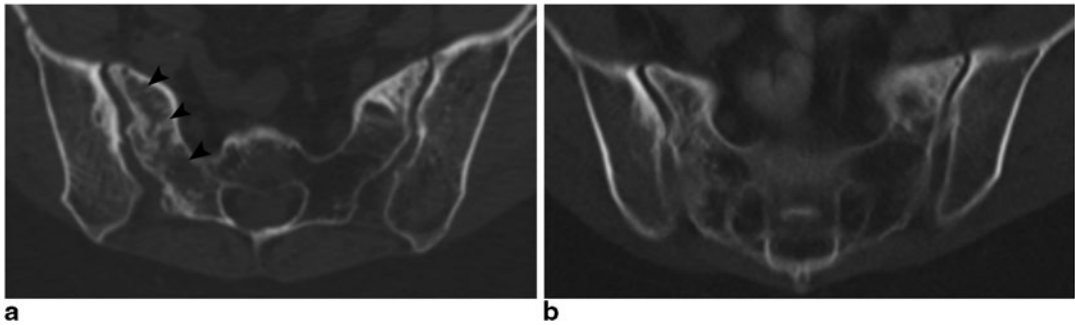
Sacral insufficiency fracture. 44-year-old female with a history of stage Ib squamous cell carcinoma of the cervix status postradical hysterectomy with pelvic lymph node dissection and postoperative chemoradiation therapy which included cisplatin as well as external beam radiation therapy involving a total dose of 45 Gy administered over 5 weeks with additional 5 Gy brachytherapy to the vaginal cuff. a CT axial images of the pelvis at the level of the S2 vertebral body obtained 3 years after completion of radiation therapy demonstrate an irregular longitudinal fracture (*ARROWHEADS*) obliquely traversing
